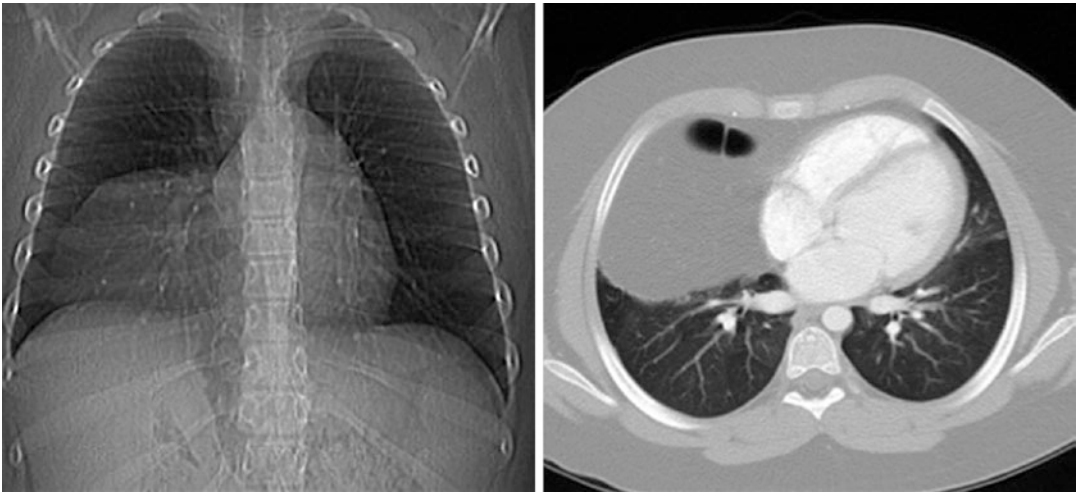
Chest X-ray and CT scan indicating a huge right-sided Morgagni hernia in a 14-year-old female
